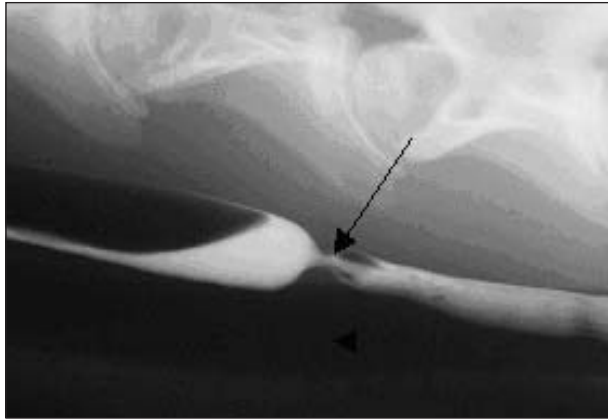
Same radiographic view as Figure 2. Contrast medium is seen filling the esophagus. A narrowed area (arrow) representing an esophageal stricture is seen in the mid-cervical region. There is dilatation of the esophagus proximal to the stricture. The trachea is also clearly visible (arrowhead).
